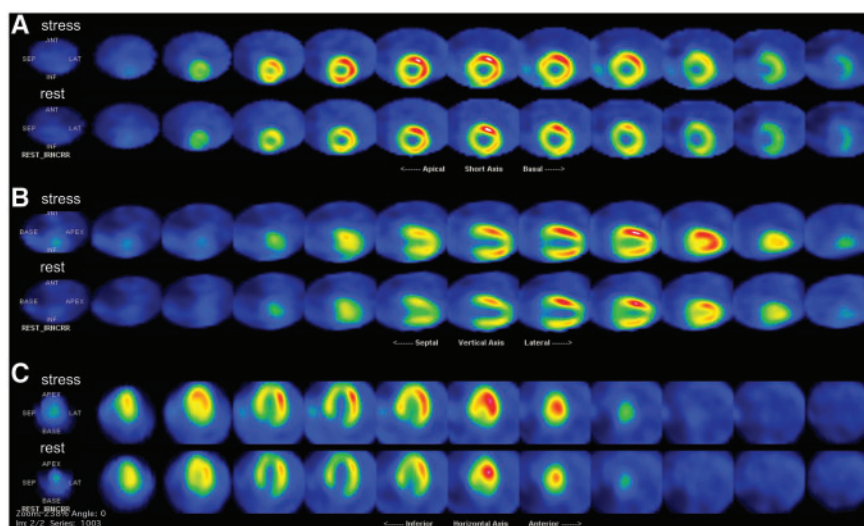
Perfusion defect associated with left bundle branch block on single photon emission computed tomography in a patient without significant lesions in left anterior descending artery. Short axis (A) and long axis (B and C) views show the defect located in septal and anterior region both at rest and stress.
